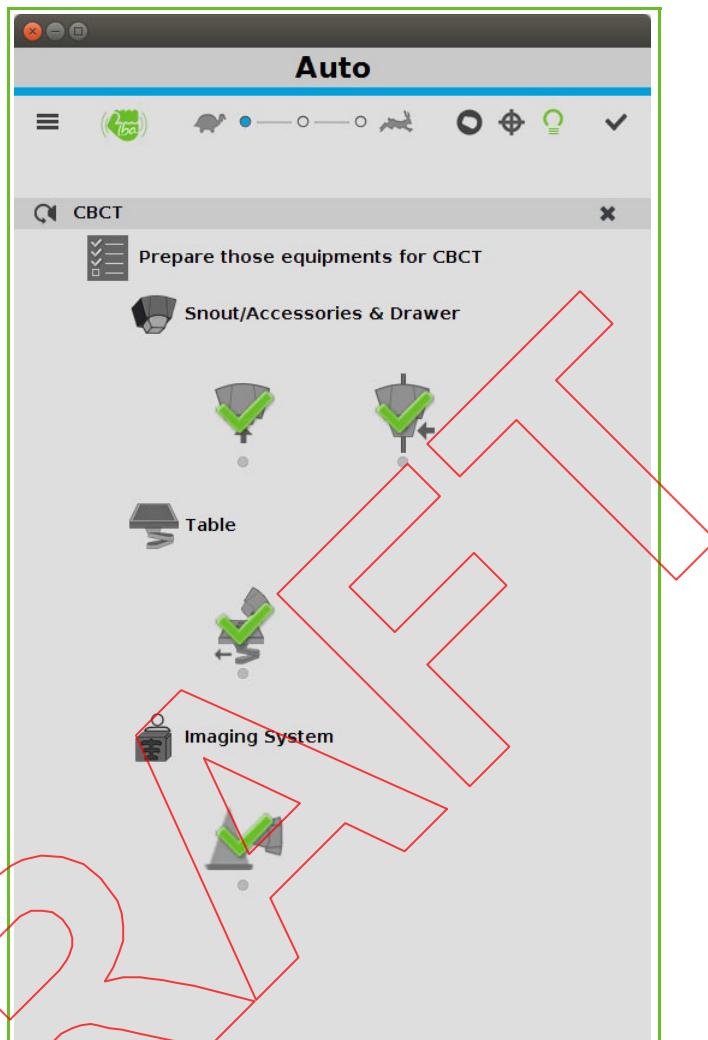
CBCT Preparation Panel - Equipment Ready (typical)
